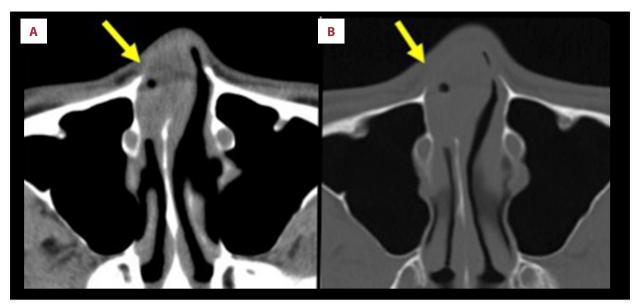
Non-enhanced computed tomography (CT) images of an intranasal pleomorphic adenoma in a 56-year-old man. (A, B) The computed tomography (CT) images show a mass measuring 14×26×25 mm in the anterior part of the right nasal cavity. The CT value of the mass is 46 Hounsfield units (HU). No fat or calcification is identified in the mass, and there are no osteoclastic changes in the surrounding bone.
